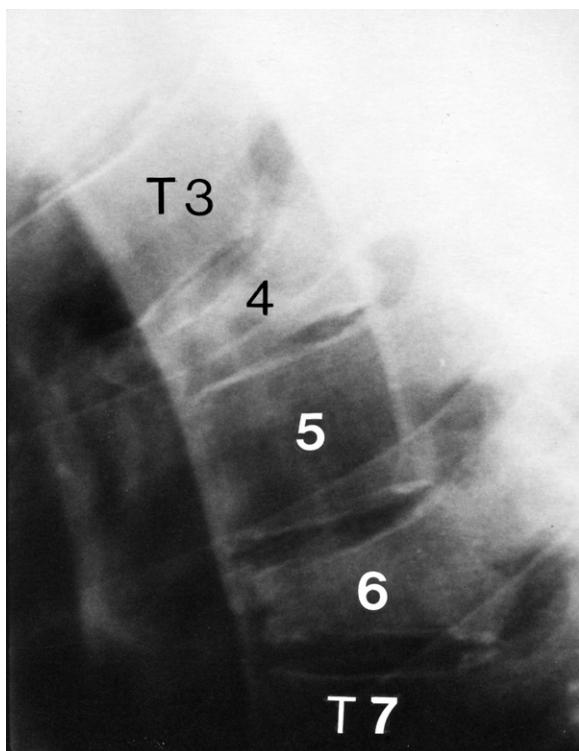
Thoracic spine lateral plain X-ray image showing thoracic vertebrae T3 to T7. Note the compression fractures at T4 and T6.
